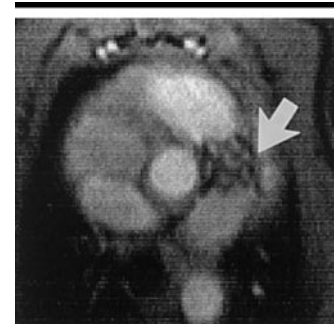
Cine MR image (8/3; flip angle, 20°; section thickness, 10 mm) acquired through wall of platinum stent clearly depicts stent morphology (arrow), including structures of wire mesh and surrounding tissue.
